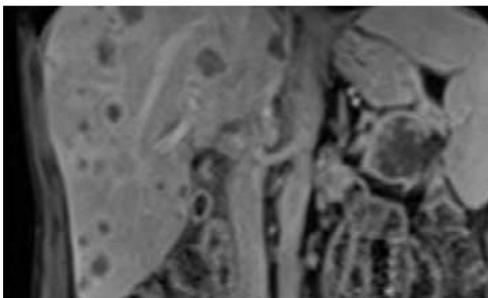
CE MRI of upper abdomen; Coronal plane; Pancreatic tail neoplasm with infiltration of spleen and liver metastases.
